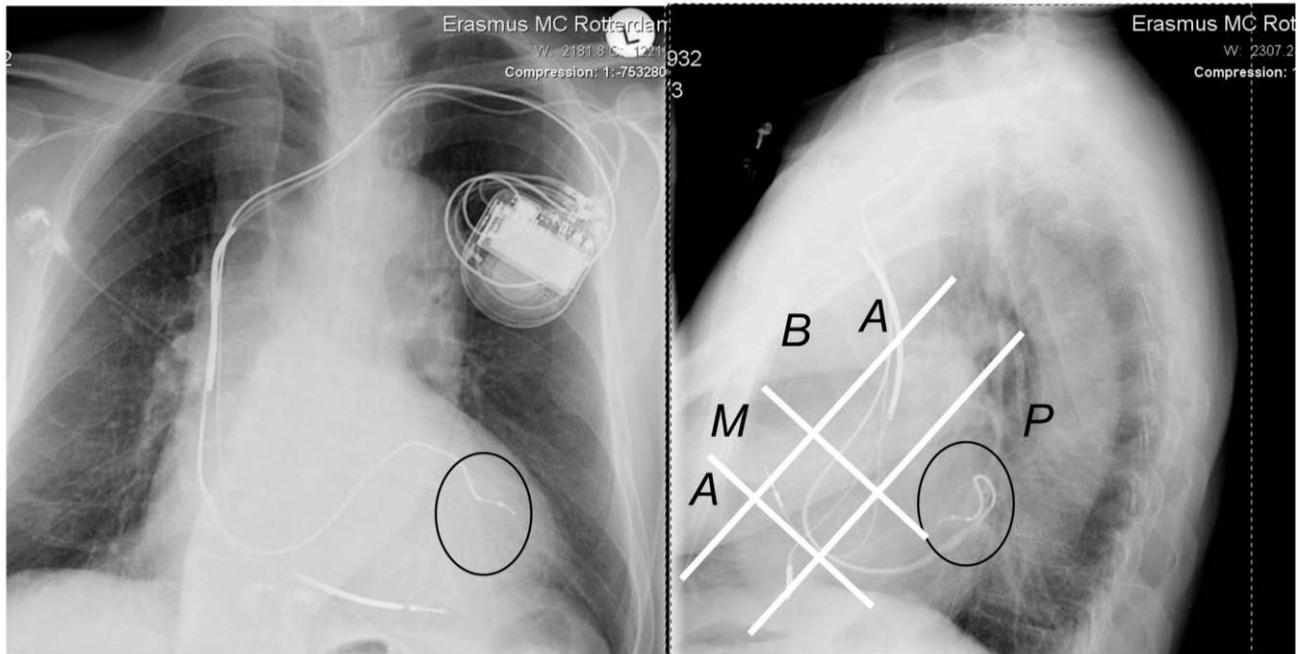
Radiographic images: the postero-anterior view to the left and the lateral view to the right. The exact lead position is confirmed from the lateral image.
